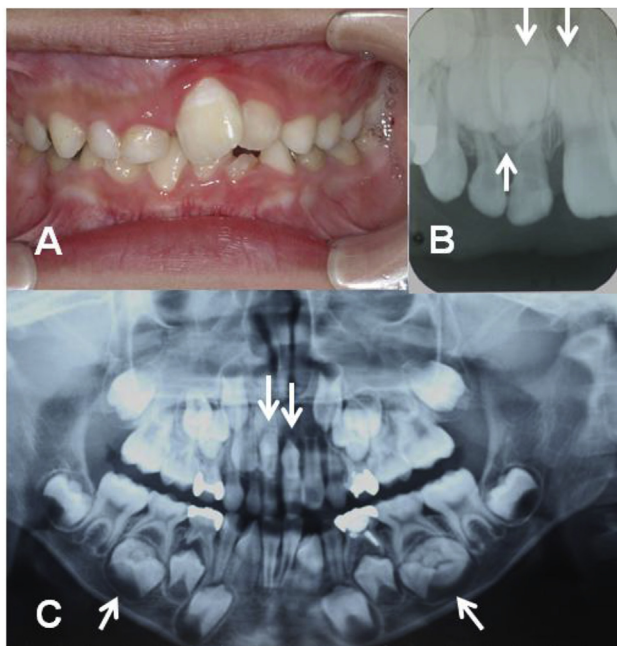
(A) Oral photograph; (B) dental; and (C) panoramic X-rays obtained at the first visit. Arrows indicate the positions of the two macrodonts and three supernumerary teeth. The macrodonts were present bilaterally in the mandibular second premolar area. One supernumerary tooth was orthodromic and the other two were inverted.
